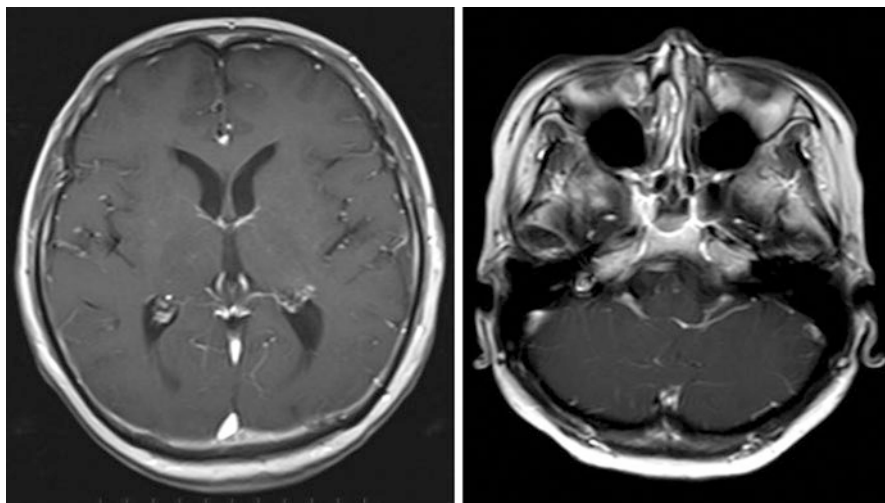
Gd-enhanced MRI scans obtained on the day after the completion of radiotherapy
